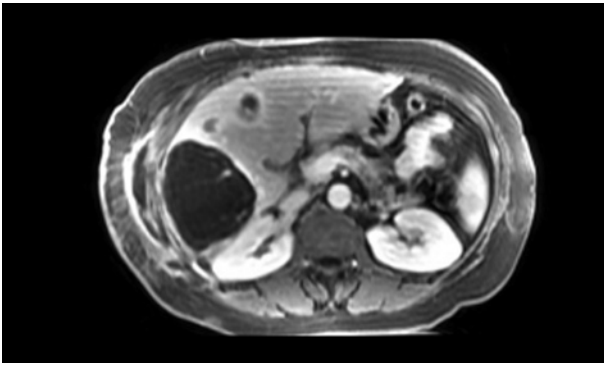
MRI image shows a dominant mass in the right hepatic lobe posterior segment measuring approximately 12 x 8 cm with rim enhancement. A decrease in signal intensity post contrast with mainly rim type enhancement is noted. The induration observed along the right lateral margin of the lower chest wall and abdomen of the patient is diffuse with the rim enhancement of the muscle.
